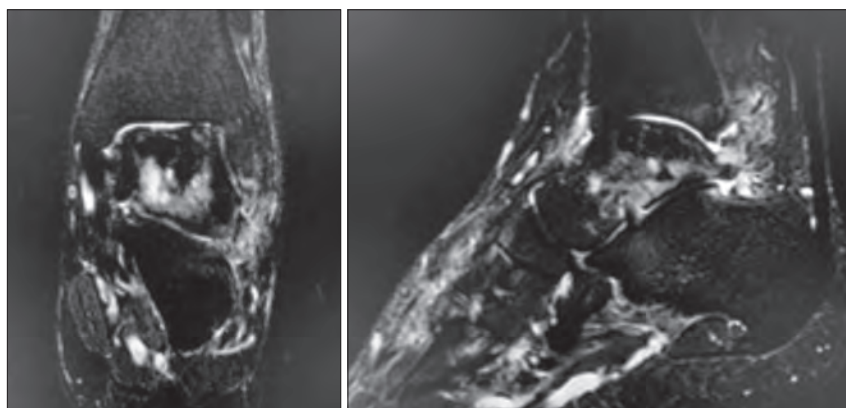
Magnetic resonance imaging (MRI) demonstrating diffuse edema throughout the talus.
